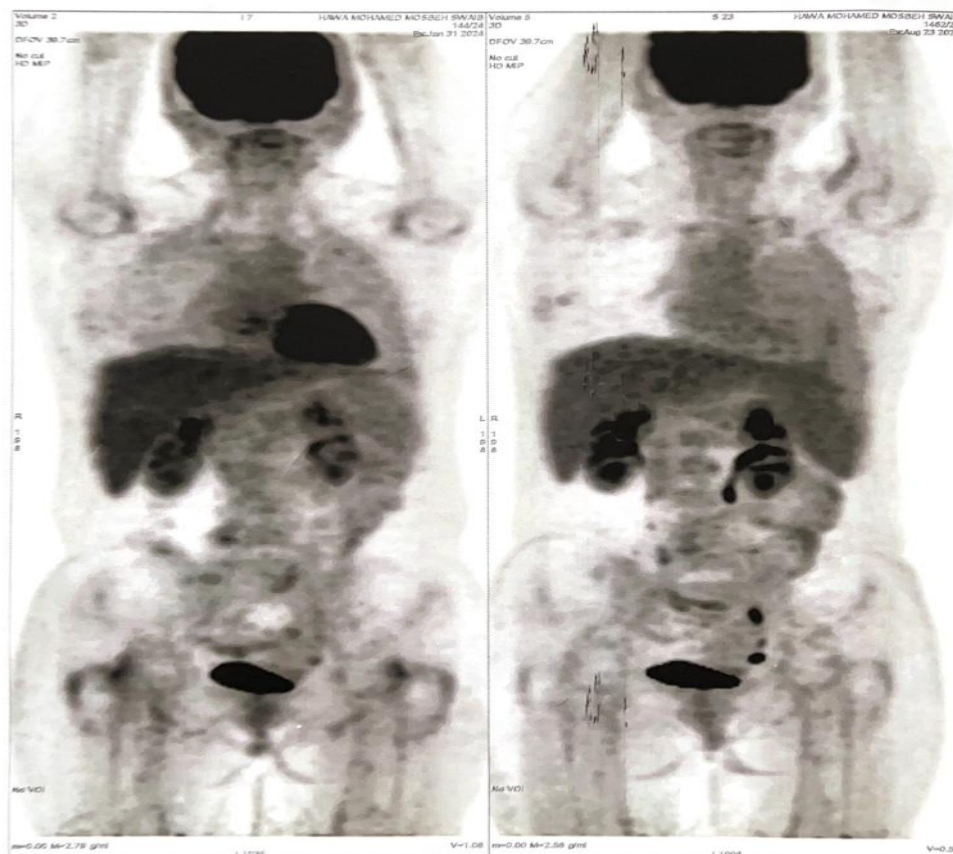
Follow-up PET-CT scans comparing the initial state (right) with the post-treatment state (left), demonstrating complete metabolic remission and resolution of previously active lymph nodes.
